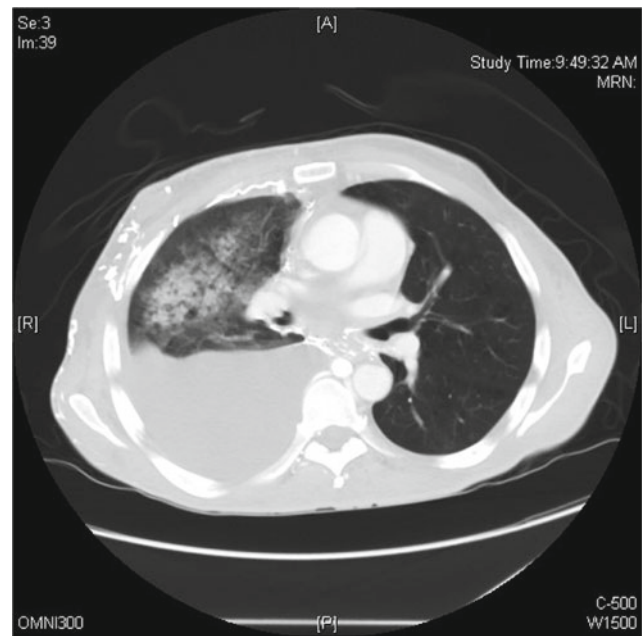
Chest computed tomography in a patient with lung cancer receiving immunotherapy diagnosed with COVID-19. Salient findings include ground glass opacities; large right-sided pleural effusion; pericardial effusion
